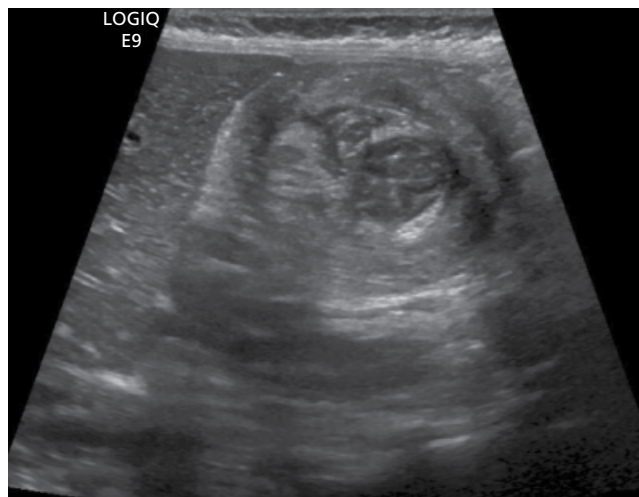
Ultrasound image of ileocolic intussusception demonstrating the target sign. Source: Reproduced from Padilla and Moses [2] with permission of Elsevier.
